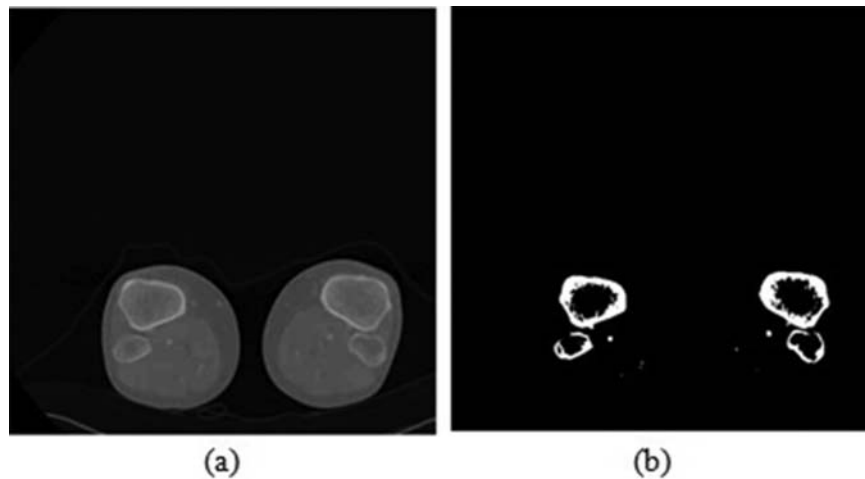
Applying thresholding on the CT image. (a) Original CT images. (b) Extracting the bone by using thresholding segmentation [30].
